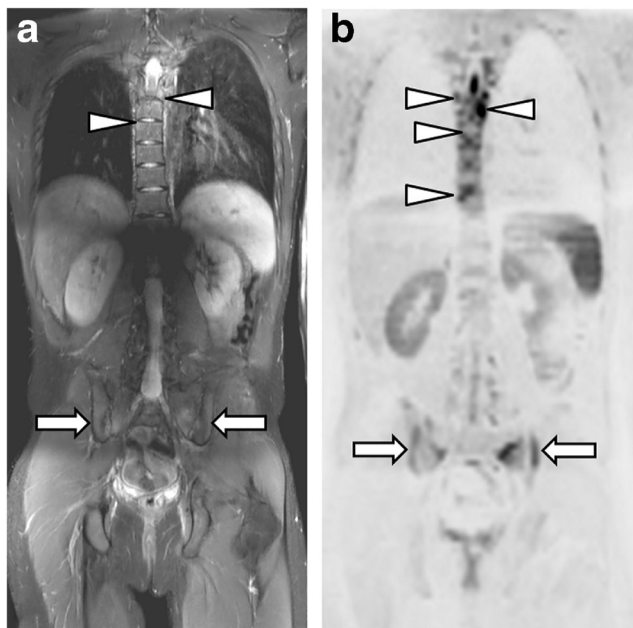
43-year old male SpA patient presenting with inflammatory pelvic pain. Comparison of STIR (A) and DWI (inverted grey scale) (B) whole body magnetic resonance imaging (MRI) sequences. Involvement of the thoracic spine (central and lateral vertebral endplates, costo-vertebral junctions) (arrowheads) and SIJ (arrows) is visible on both images but much more evident on DWI, due to background signal suppression
